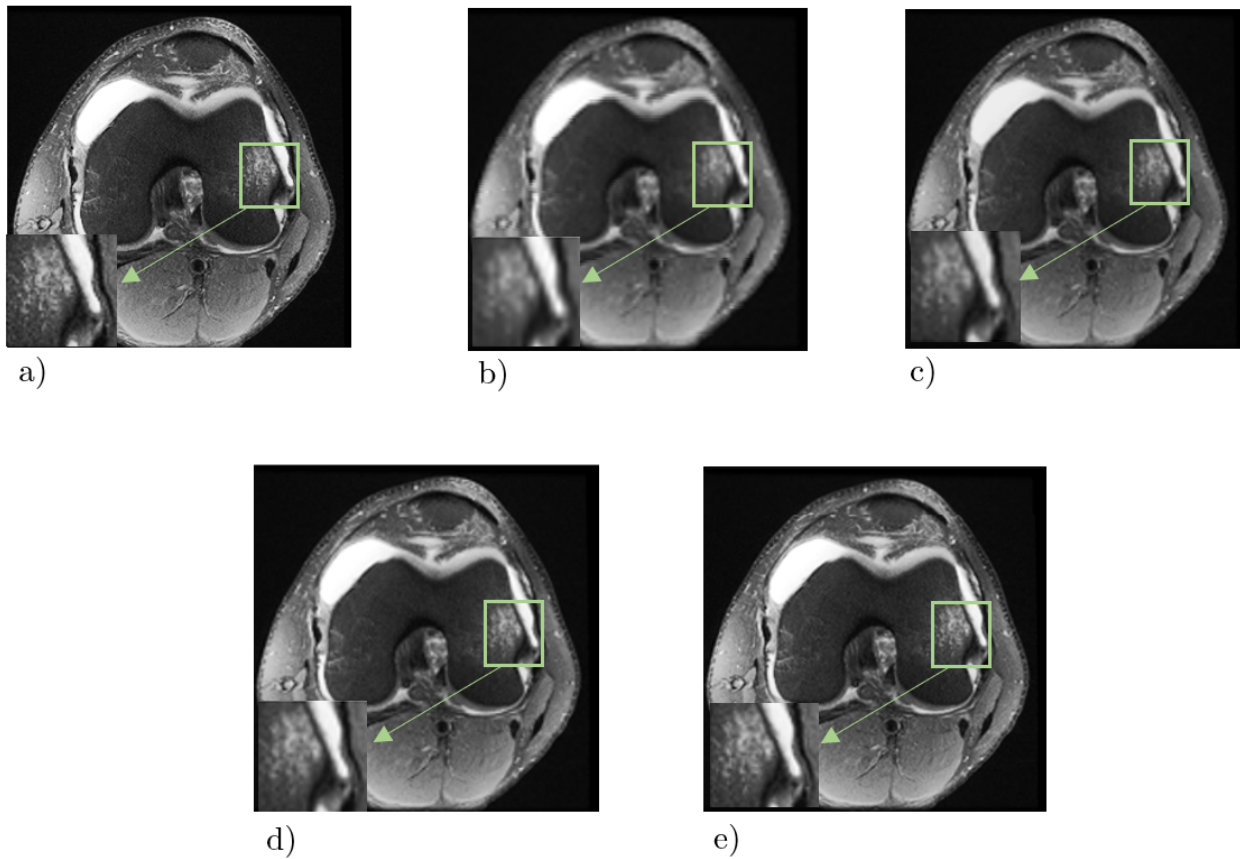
T2 Weighted Axial MRI. a) Original *HR* image. b) X2 factor *LR* image. c) SRCNN. d) ExSRCNN. e) RBSRCNN
